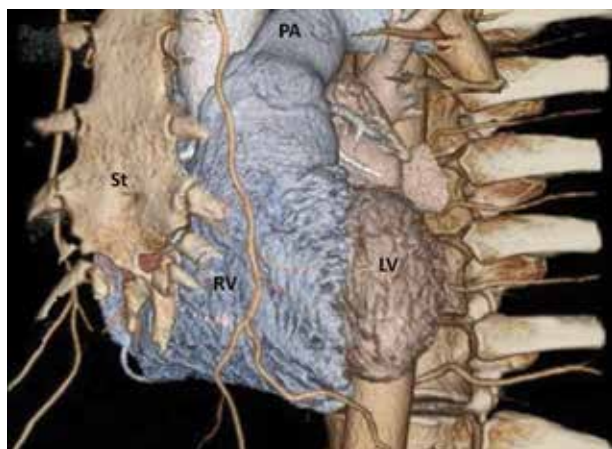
Computed tomography three-dimensional reconstruction of the heart within the chest as "electronic cast" obtained by making soft tissues completely transparent and increasing the opacity of intracavitary contrast. This modality shows the spatial relationships between right ventricle (RV) and other anatomical structures within the thoracic cavity. (Courtesy of Dr. Francesco Faletta); LV — left ventricle; PA — pulmonary artery; St — sternum
